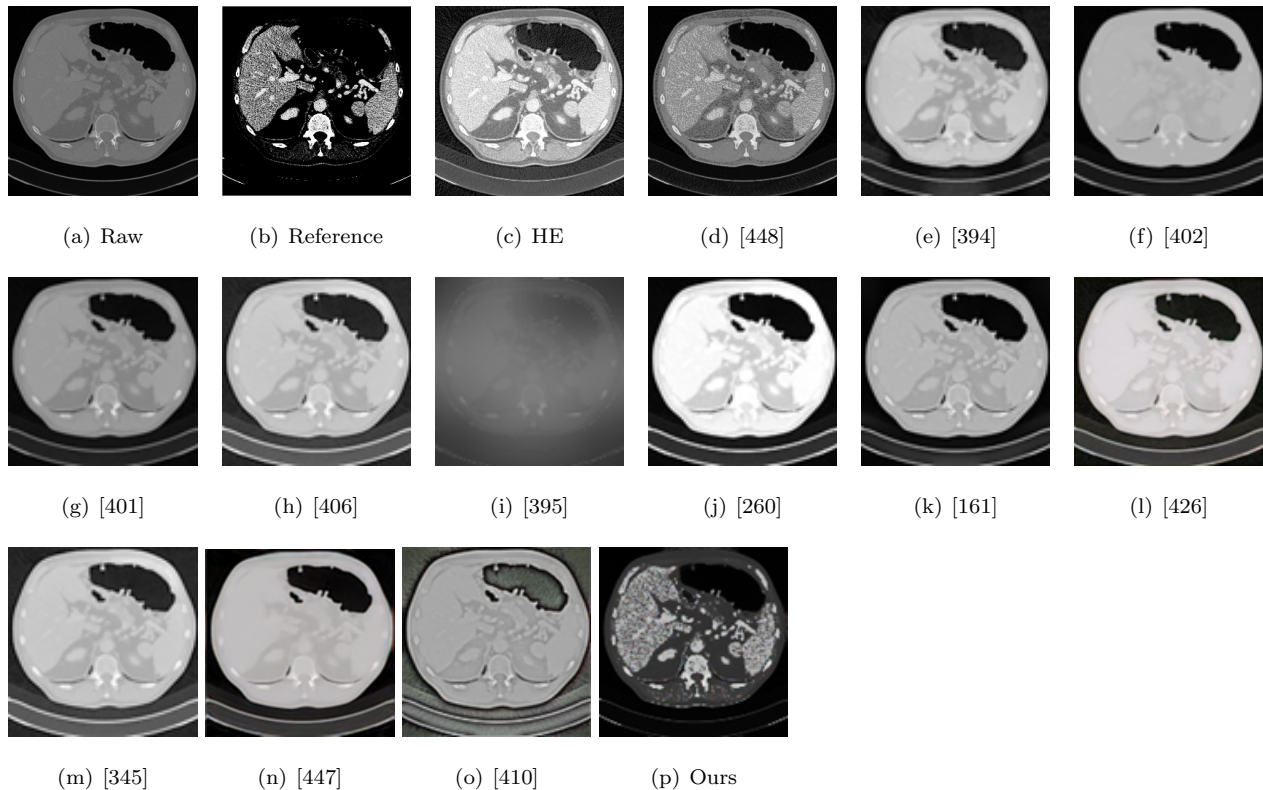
Visual results of CT scan enhancement for the Sliver07 dataset [8]. HE represents histogram equalization.
